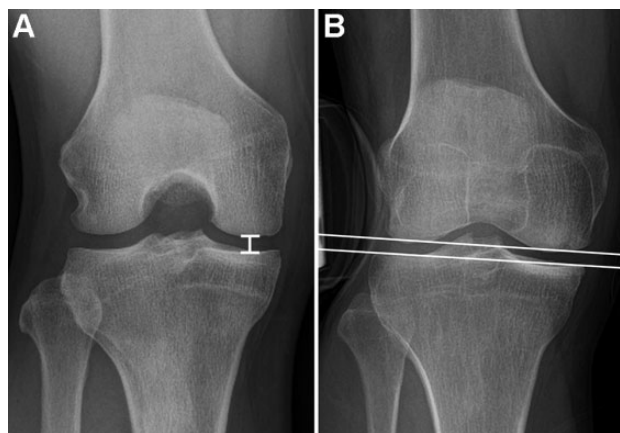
Measurement of (A) medial joint space width on Rosenberg view and (B) valgus stress joint line convergence angle on valgus stress radiographs.
